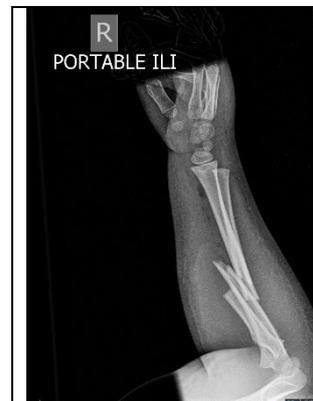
X-ray radius-ulna during patient's first presentation
